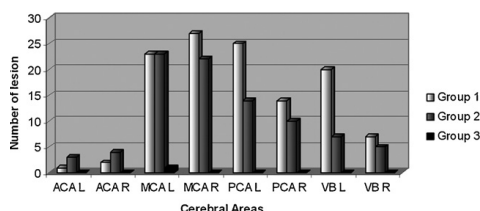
Distribution of DW-MRI lesions in the cerebral areas. Number of lesions counted in the different cerebral areas. ACA: anterior cerebral artery; MCA: middle cerebral artery; PCA: posterior cerebral artery; VB: vertebrobasilar arteries; L: left; and R: right.
